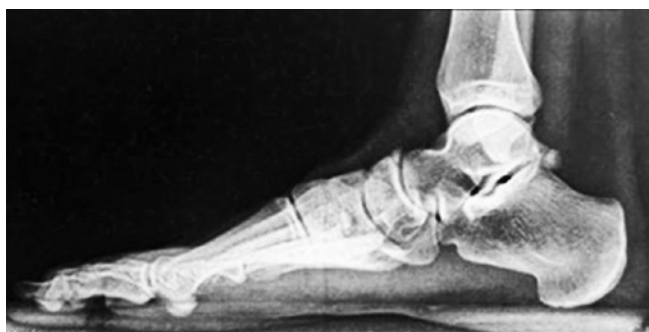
Presence of os trigonum on ankle radiograph in profile position.
